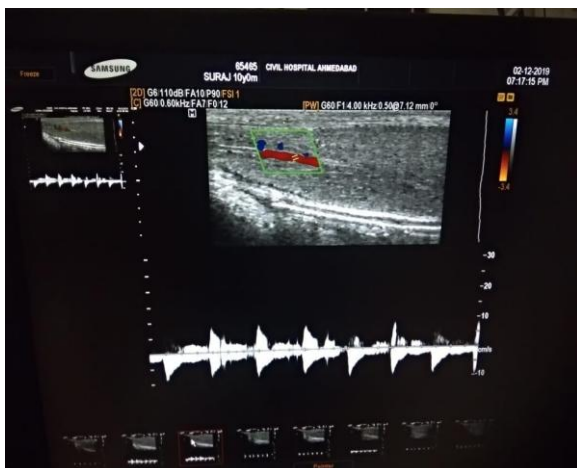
Doppler showing immature arterial hemodynamics in pre pubertal male
